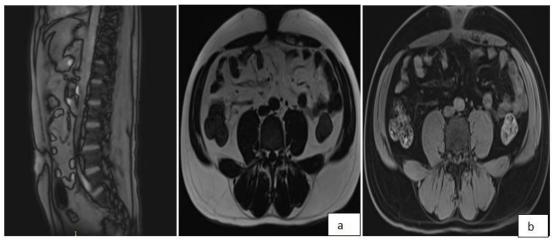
Abdominal MRI: Axial T1 vibe dixon (a), Axial T1 vibe Dixon with gadolinium(c); showing an extraperitoneal collection of the anterior abdominal wall infiltrating the rectus muscles, extending from the umbilicus to the bladder dome, with a cutaneous fistulous pathway
